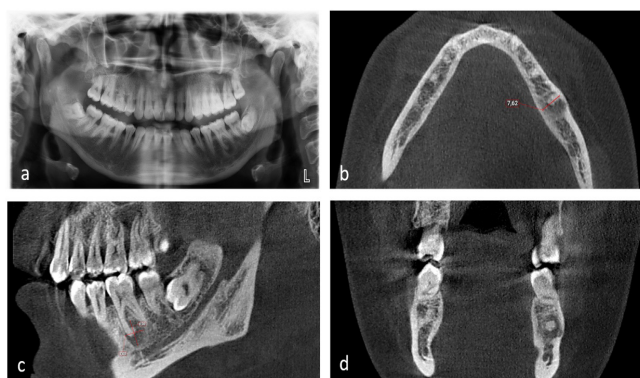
a. Panoramic radiography of the patient (year 2015) with a well-defined radiolucent lesion in the apex of the left mandibular first molar, b. CBCT showed minimal expansion in the axial plane and thinning of the buccal cortical plate, c. Hyperdense internal content adjacent to the molar root in sagittal plane, d. Thinning of the buccal cortical plate can be observed in coronal plane.
